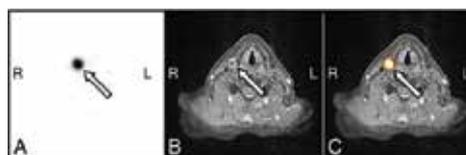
¹²⁴I PET/MRI of the neck in recurrent DTC. A: axial PET. B: axial T1-W TSE sequence after contrast agent. C: axial PET/MR fusion. 71-year-old male patient with a follicular pT2 pN0 DTC, 8 years after thyroidectomy and RIT with 6.0 GBq ¹³¹I. The arrows mark a lymph node metastasis right cervical.
